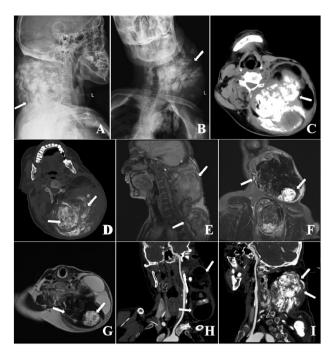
Imaging findings: (A) X-ray orthopantomograph and (B) X-ray lateral view. The shadow of a large soft tissue mass is seen subcutaneously in the left posterior aspect of the neck. (C and D) Preoperative CT findings: Massive lobulated mixed-density soft tissue mass shadow seen in the left side of the neck. (C) Soft tissue window and (D) bone window. (E-G) MRI findings. (E) T1-weighted MRI in the sagittal position, (F) T2-weighted in the coronal position, (G) T2-weighted MRI in the axial position. (H and I) CT findings after chemotherapy: Reduction in tumour size seen after chemotherapy. (H) Coronal and (I) sagittal positions.
